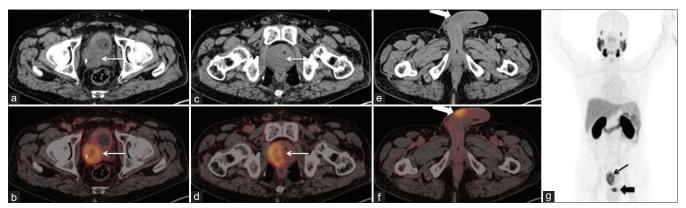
CT images (a, c, e), corresponding PSMA PET/CT images (b, d, f) and maximum intensity projection (MIP) image (g) revealed PSMA avid lesion epicentered along the right lobe of prostate gland (SUVmax- 14.40) (a-d, thin white arrows; g, thin black arrow). Also, there was a solitary metastatic deposit in the penile shaft (SUVmax- 13.7) (e, f, thick white arrow; g, thick black arrow)
